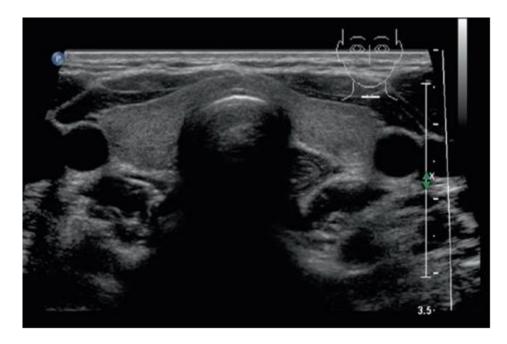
Normal Ultrasound Appearance of the Thyroid Gland
